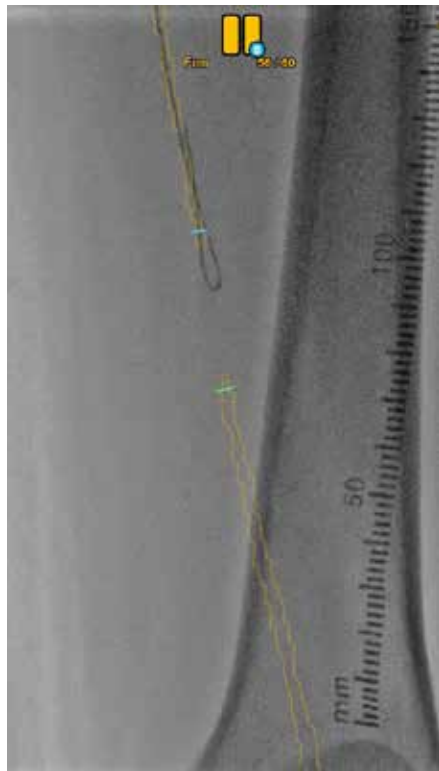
Crossing the lesion under CT fusion.
